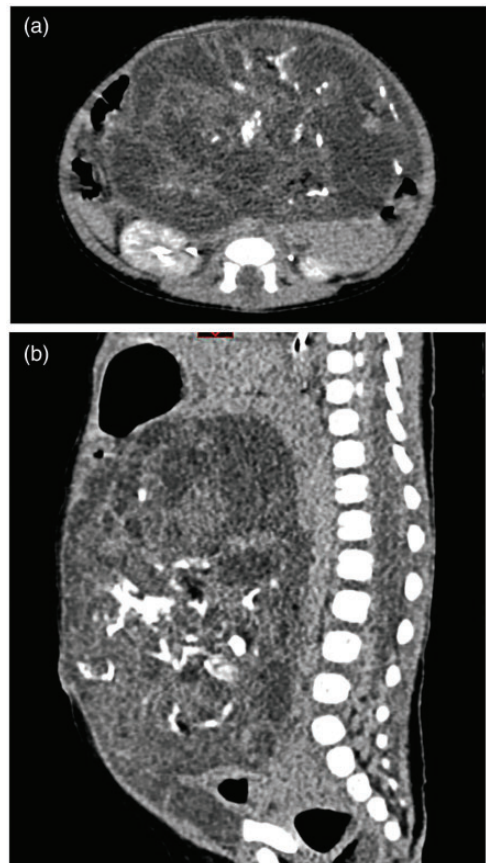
Abdominal computed tomography scan. Images show a large cystic, solid mass with punctate calcifications.
